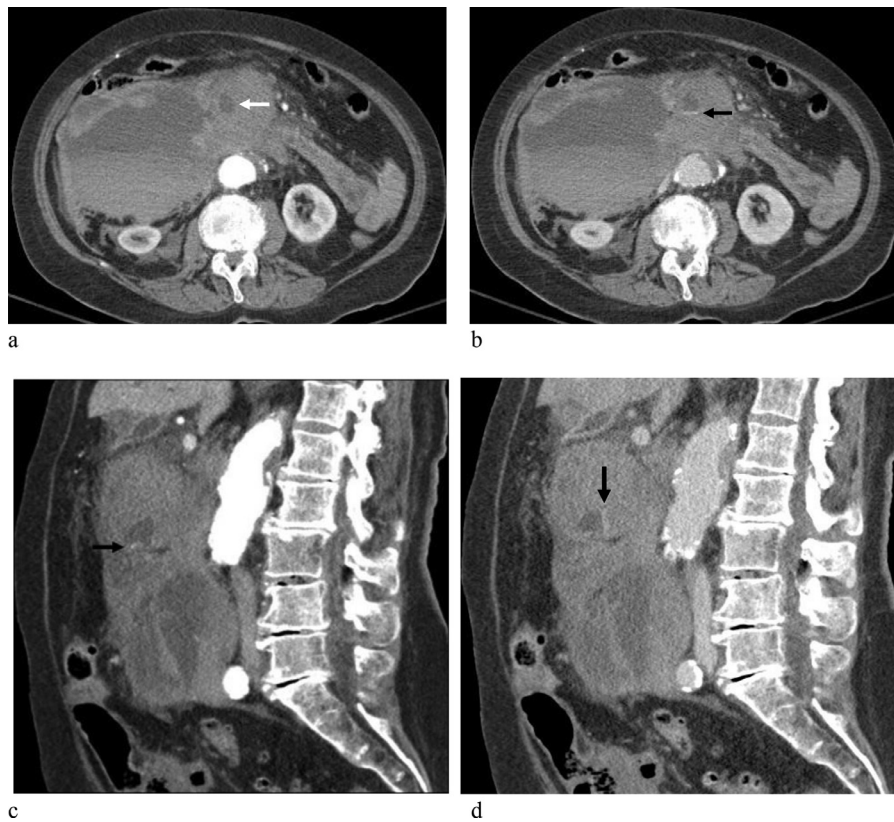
Axial arterial (a) and delayed (b) images from the contrast enhanced CT angiogram of the abdomen demonstrate an area of relative hypodensity on arterial phase images (white arrow) followed by layering of the hyperdense contrast on delayed imaging (black arrow). Sagittal arterial (c) and delayed (d) images from the contrast enhanced CT angiogram of the abdomen demonstrate a bright spot on the arterial images (black arrow) followed by layering of the hyperdense contrast on delayed imaging (black arrow). Findings are consistent with active extravasation of contrast.
